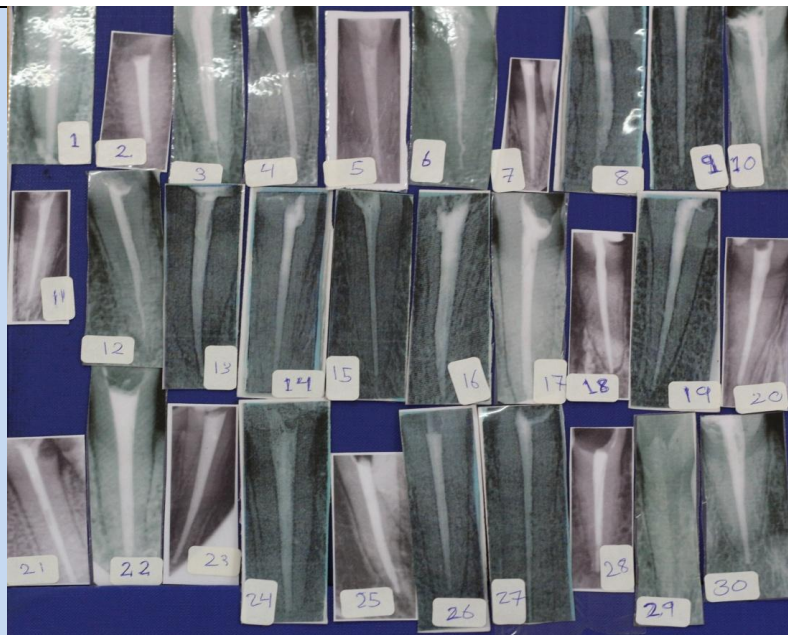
Radiographs represent ante-mortem labelled from (1-30)
